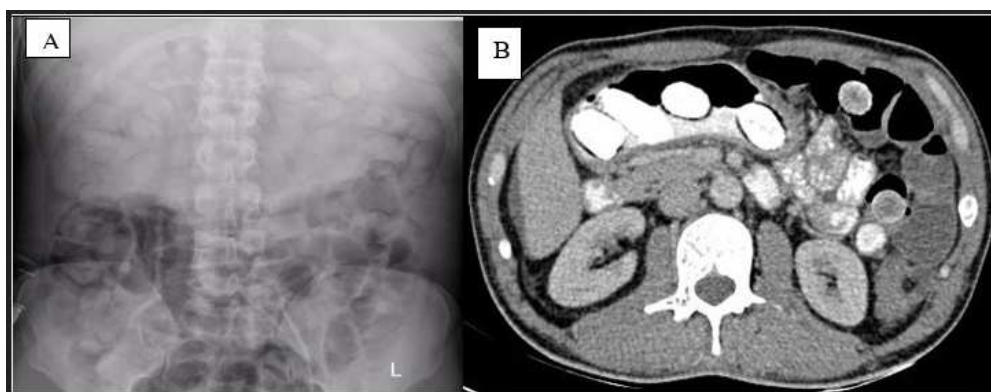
(A) supine abdominal non-contrast X-ray showing multiple radio dense packets, double condom signs and rosette-like findings as described in text, (B) CECT- scan of abdomen (axial section) showing multiple dense packets with surrounding air in gastro-duodenal junction
